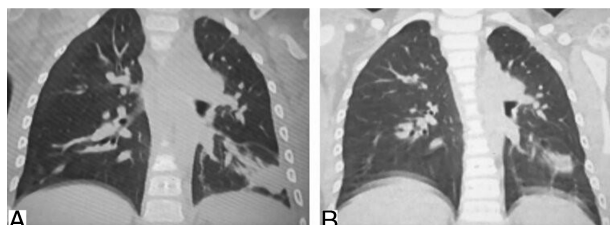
HRCT imaging lung. (A): before treatment. (B): after of 10 months tocilizumab
